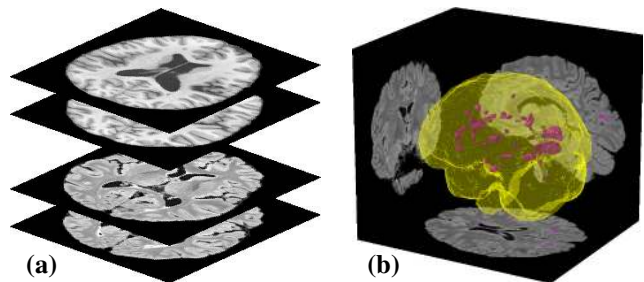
Lesion segmentation. Starting from a 3D image stack (a) containing $c > 0$ image contrasts (here the $c = 2$ is for FLAIR and T_1 -w images), we consider a geometric brain model to find the WM lesions of an MS patient (b).
